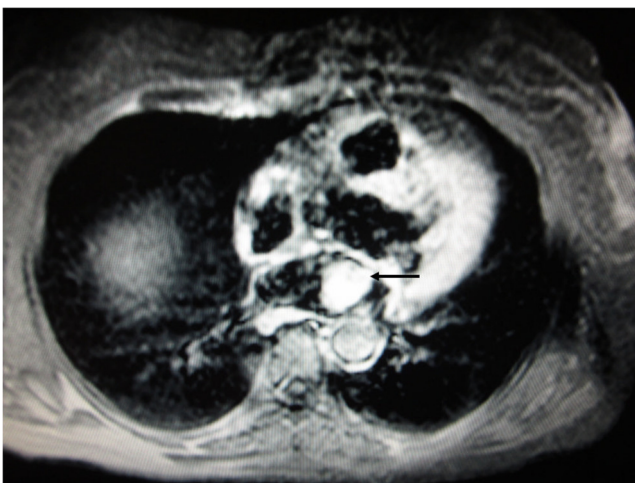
Cardiac MRI showing a mobile pedunculated tumor 2.2×2.5 cm in diameter (arrow), joined to the lateral wall of the left atrium.
